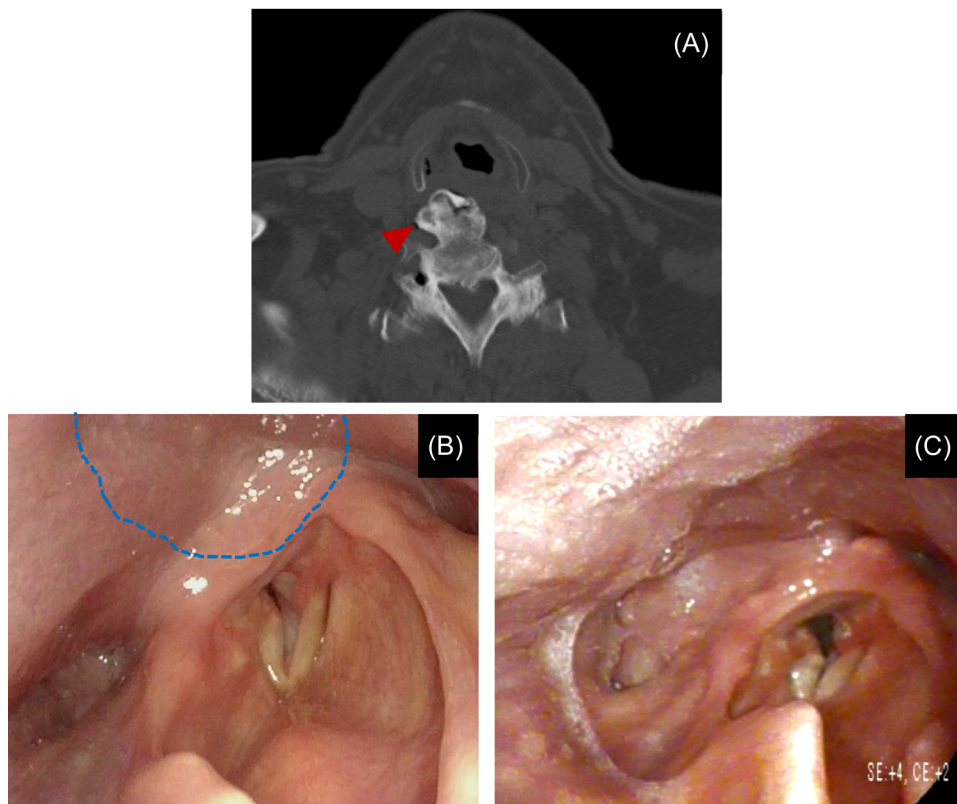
Patient 2: (A) Axial CT scan shows an osteophyte mass (red arrow). (B) Preremoval nasolaryngoscopy view of the VFs with DISH (blue outline). (C) Postremoval nasolaryngoscopy view of the VFs. CT, computed tomography; DISH, diffuse idiopathic skeletal hyperostosis; VF, vocal fold.
